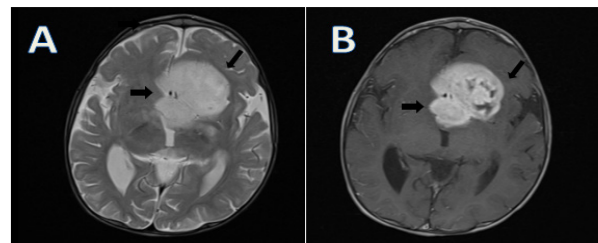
Cranial magnetic resonance imaging (MRI) showing a mass filling the suprasellar cistern and causing compression at the base of the third ventricle (A), and a mass lesion with intense contrast enhancement (B)
